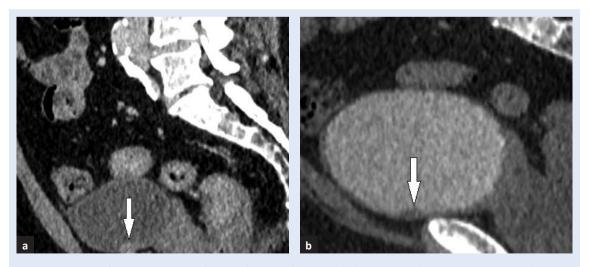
Sagittal reformatted images of a small (< 10 mm) urinary bladder tumour detected on CT urography in a) nephrographic phase as an enhancing lesion, and b) excretory phase as a contrast filling defect.
